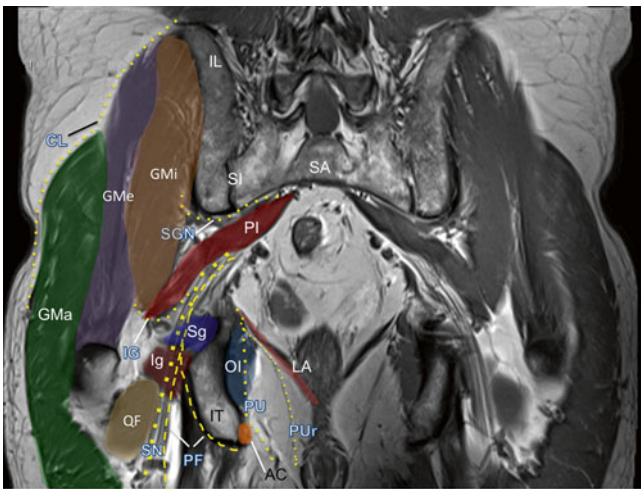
Coronal MRI of the pelvic structures. *AC* Alcock's canal, *CL* cluneal nerve, *GMa* gluteus maximus muscle, *GMe* gluteus medius muscle, *GMi* gluteus minimus muscle, *IG* inferior gluteal nerve, *Ig* inferior gemellus muscle, *IL* iliac crest, *IT* ischial tuberosity, *LA* levator ani muscle, *OI* obturator internus muscle, *PF* posterior femoral cutaneous nerve, *PI* piriformis muscle, *PU* pudendal nerve, *PUr* rectal branch of the pudendal nerve, *QF* quadratus femoris muscle, *SA* sacrum, *Sg* superior gemellus muscle, *SGN* superior gluteal nerve, *SN* sciatic nerve (Image courtesy of Andrea Trescot, MD)
